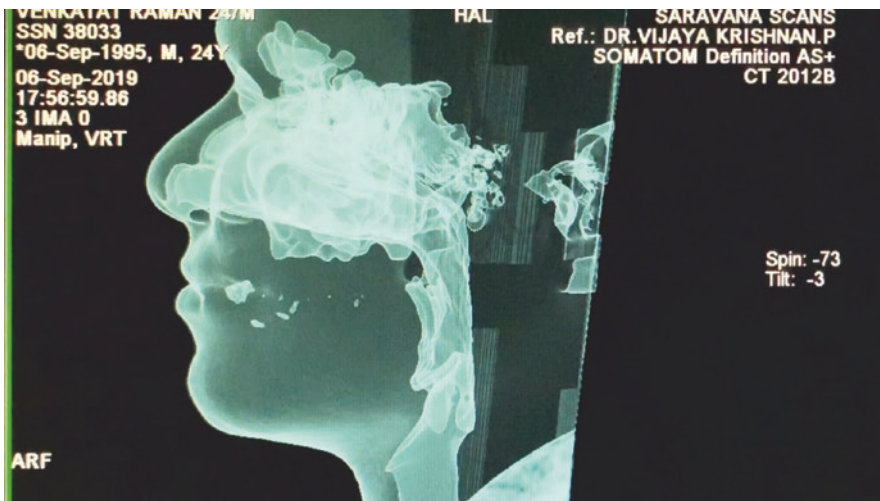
CT airway volumetric analysis from nasal cavity to hypopharynx
